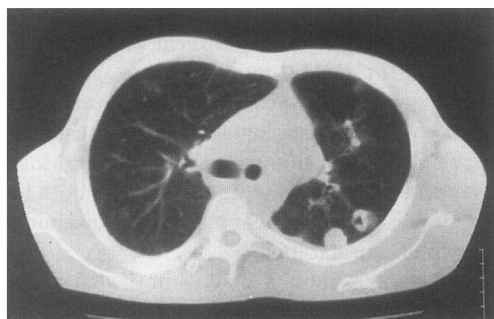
CT scan of the thorax showing bilateral cavitating nodules.
